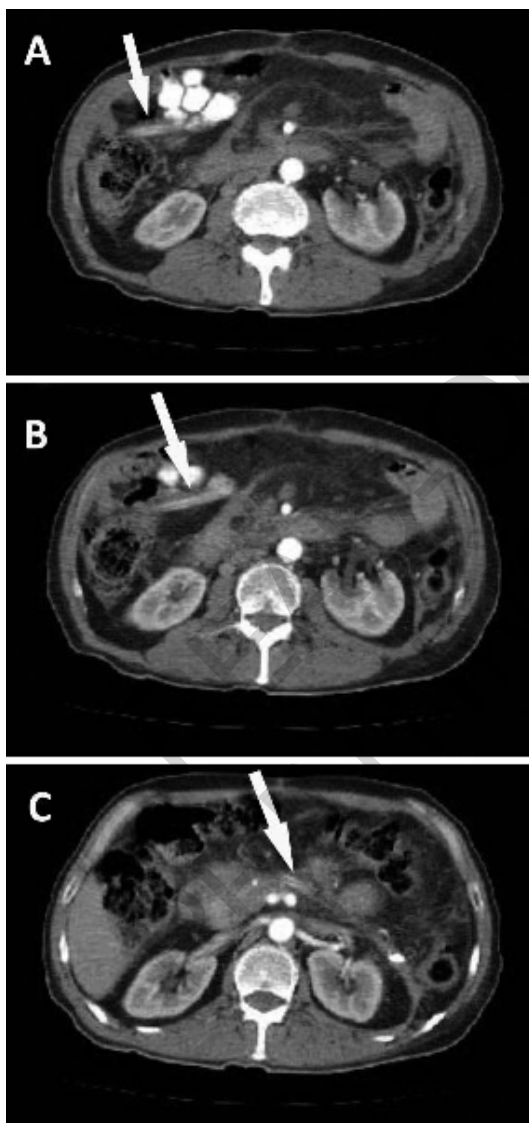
A-C.) Abdominal CT scan images taken for preoperative planning to evaluate the size of the fistula tract and its wall thickness and rule out any associated intra-abdominal collections (white arrows indicate the surgically placed drainage catheter throughout the pancreatic bed)
